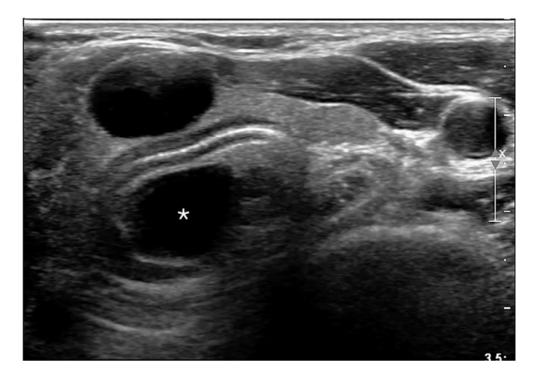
Transverse sonogram demonstrates a 1.5×1 -cm-sized movable thyroid cyst. Another cyst (asterisk) is noted within the tracheal lumen, specular to the thyroid cyst. Anterior tracheal wall is flattened between 2 cysts.
